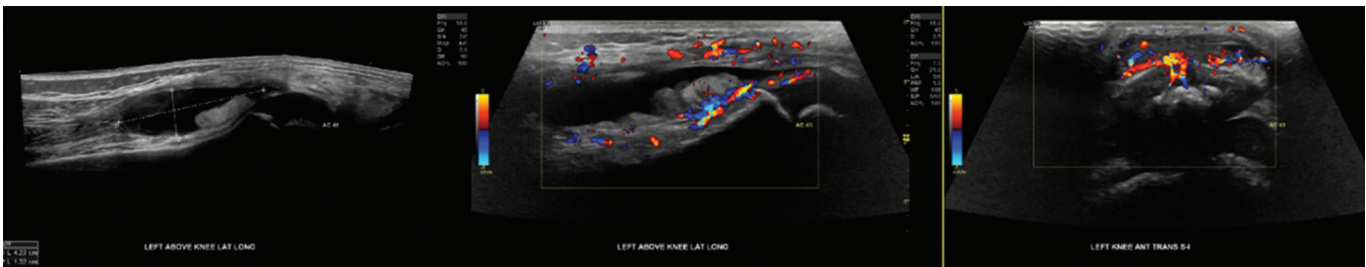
Left knee ultrasound showing 4.2 x 1.3 cm hypochoic prepatellar fluid collection. No significant knee effusion was detected.
